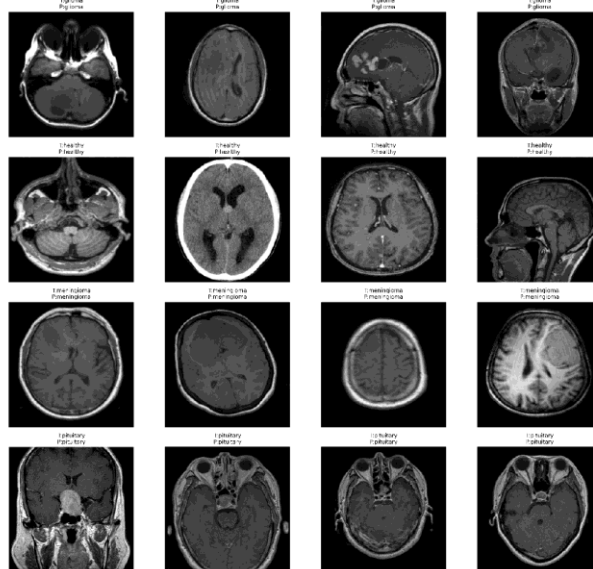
ResNet50 Correctly Classified MRI Images Results.
